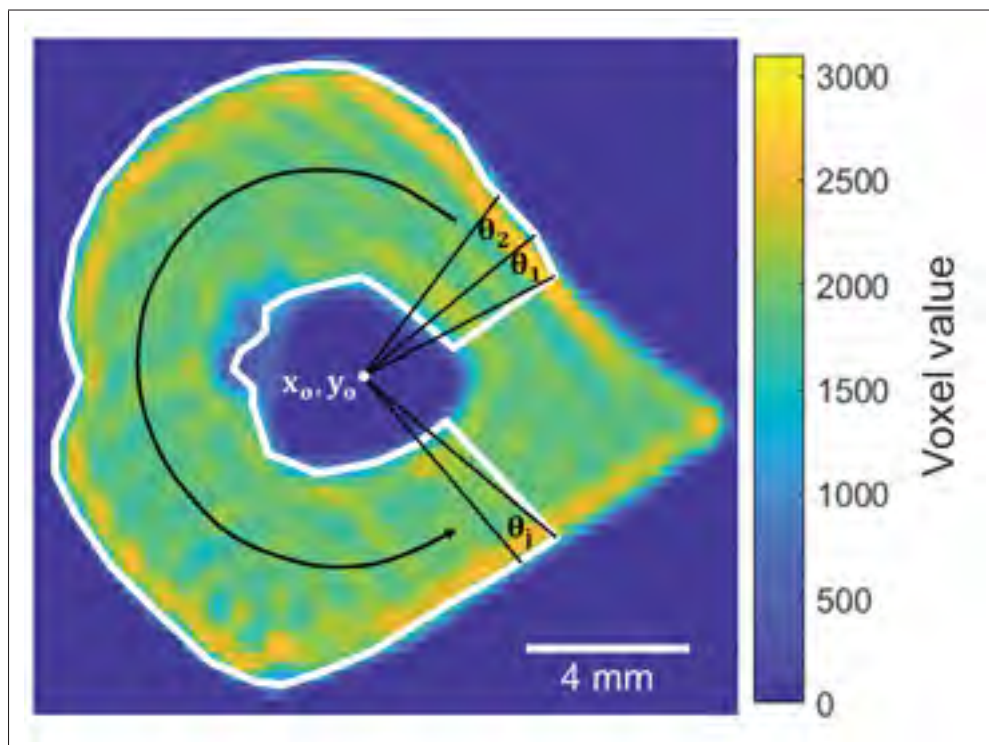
Computed tomography (CT) image taken at the middle 1/3 radius, with the white solid lines showing the ROI of the axial transmission measurements.
